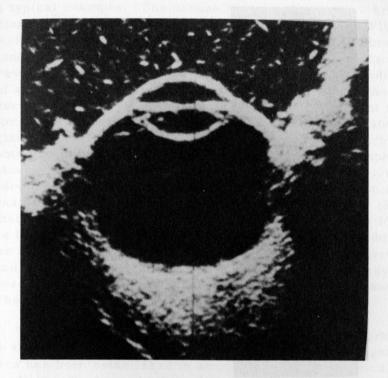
Ultrasonotomogram of the Human Eye (Baum)
